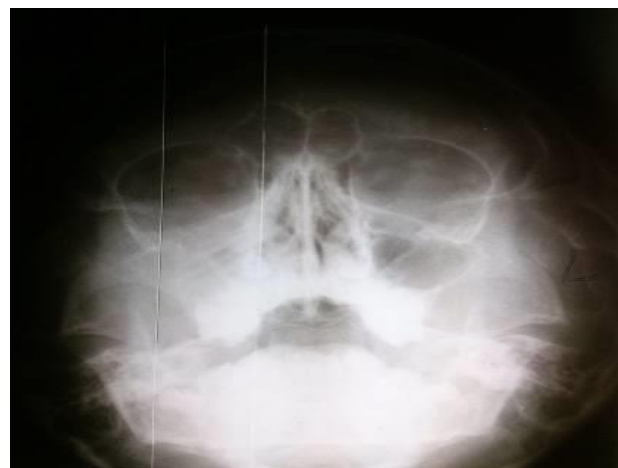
The plain x-ray demonstrating an opacity with a suspicious foreign body
